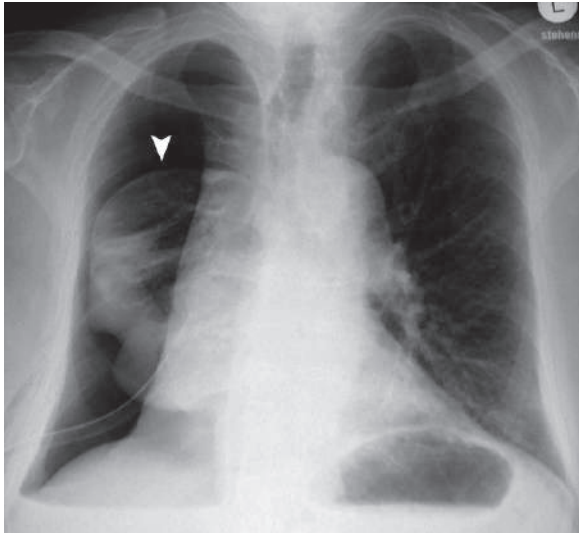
Posteroanterior chest radiograph shows right pneumothorax with lung collapse (*arrowhead*)
